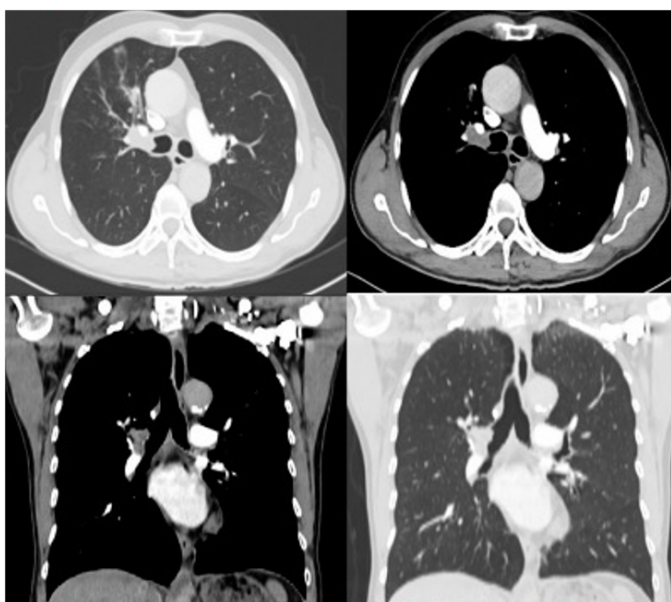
Thorax CT image of an endobronchial tumor extending towards the main bronchus at the entrance of the right upper lobe.
